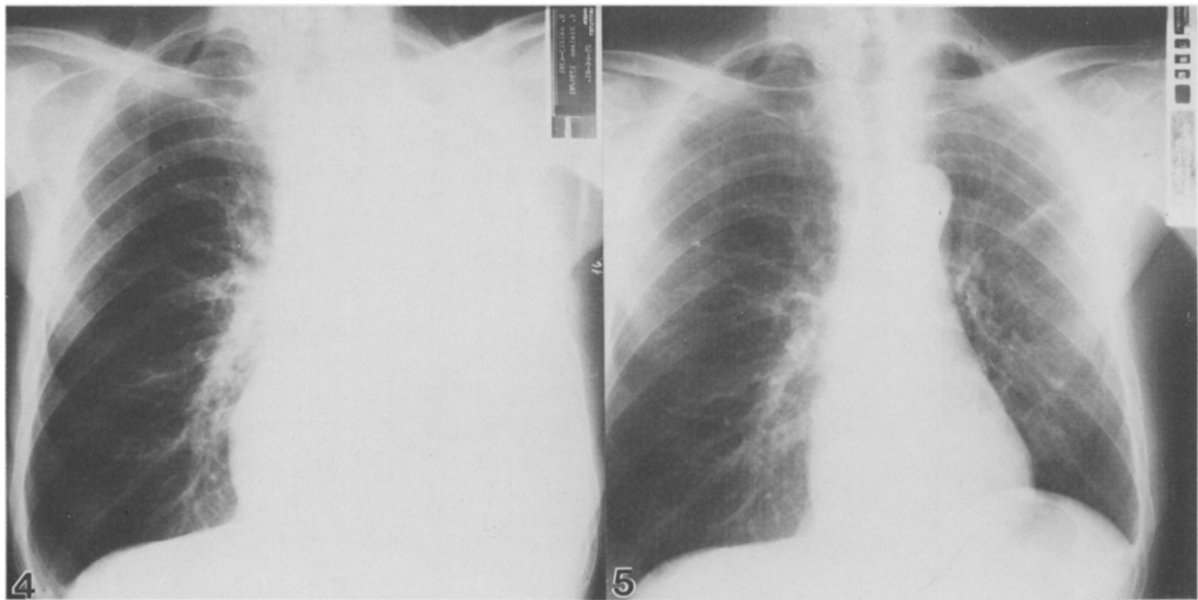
Chest X-rays before treatment.
